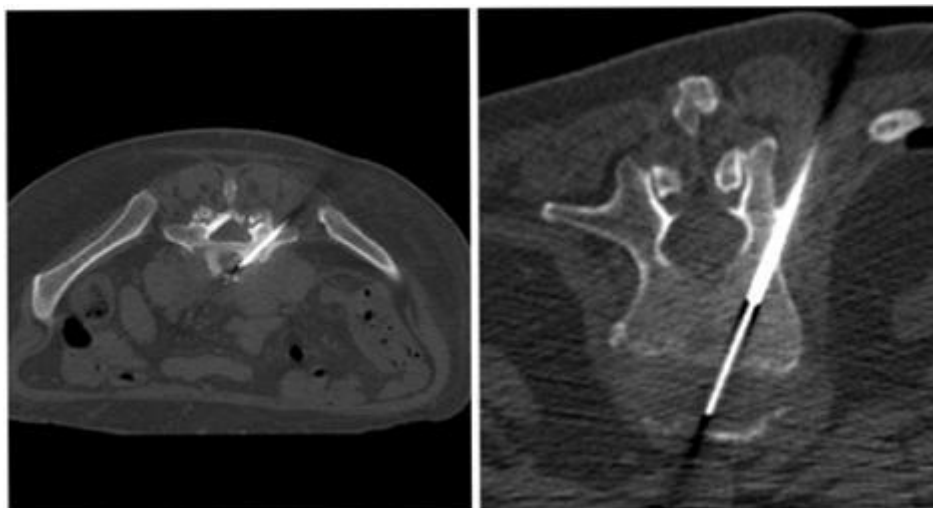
CT-guided biopsy demonstrating the biopsy needle penetrating into disk space.
